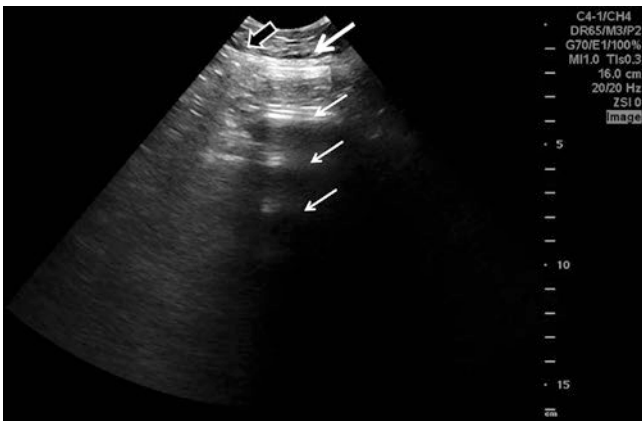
Ultrasound image of the pneumoperitoneum. Enhancement of peritoneal stripe (*large arrow*) and reverberation artifacts (*small arrow*) detected in the right hypochondrium scan with convex probe in a patient with pneumoperitoneum with adjacent area of normal air within the lumen of the gastrointestinal tract (*empty arrow*). Image courtesy of Bret Nelson
